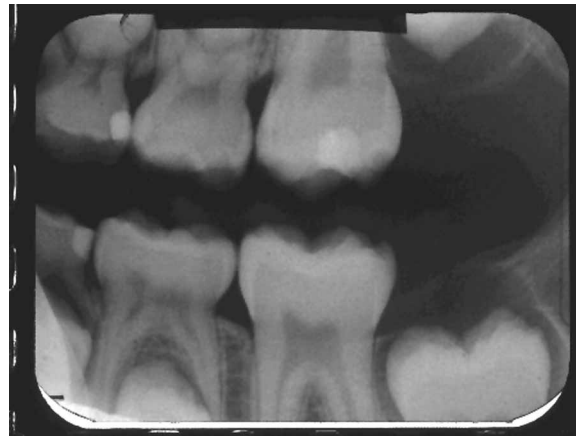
Radiograph of maxillary 1st primary molar (DO) restored with Tetric-Flow/Excite restoration after 2 years. Marginal adaptation score 3 not acceptable.
